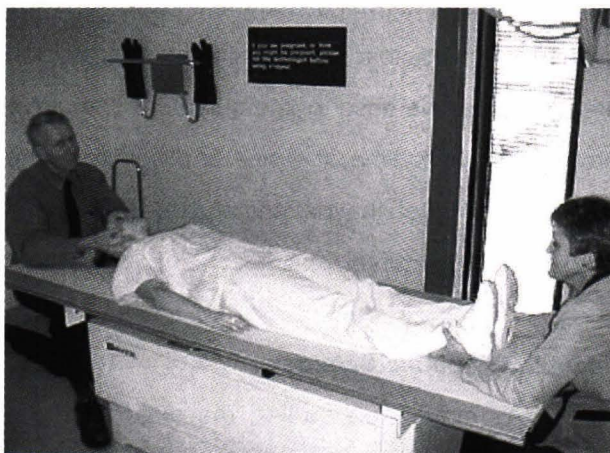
Traction or stretching procedure for radiographic evaluation the curve flexibility.
